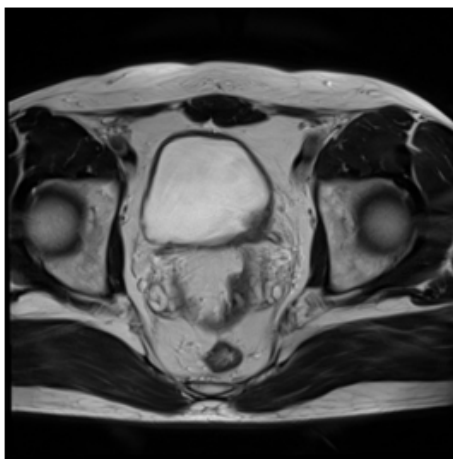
Transverse MRI section post endoscopic resection.
